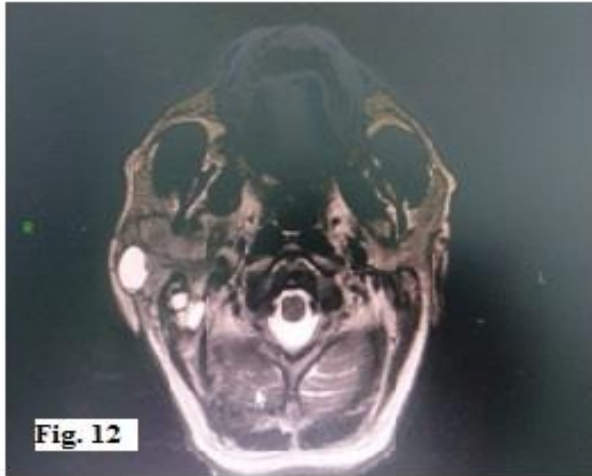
& 13 Showing axial view of CT (contrast enhanced) & MRI of head with right parotid mass
